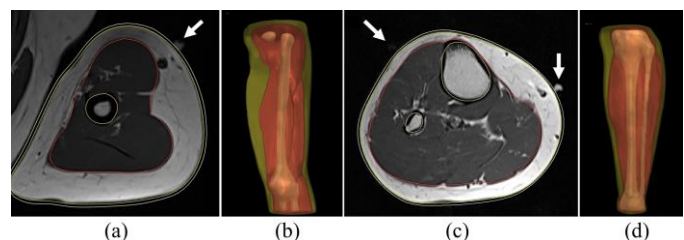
Examples of smoothed surface meshes and markers position from MRI images. White arrows indicate the MRI markers for electrode placement. (a) Axial slice of arm. (b) 3D representation of segmented arm. (c) Axial slice of lower leg. (d) 3D representation of segmented lower leg. Bone mesh in brown, muscle in red, fat in yellow, and skin in white (only in (a) and (c)).
